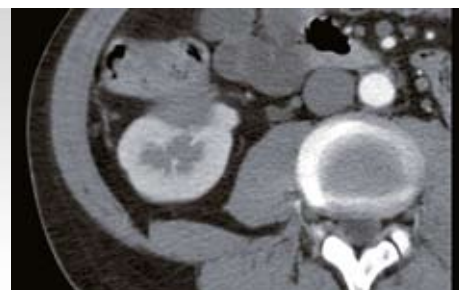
Despite the mild chronic renal failure, contrast-enhanced CT was performed after hyperhydration using reduced dose of iodinated contrast media (1 mL/kg body weight). The lesion was perfectly homogeneous and did not enhance at all. There was no fat interface between the tumor and the right colon.
